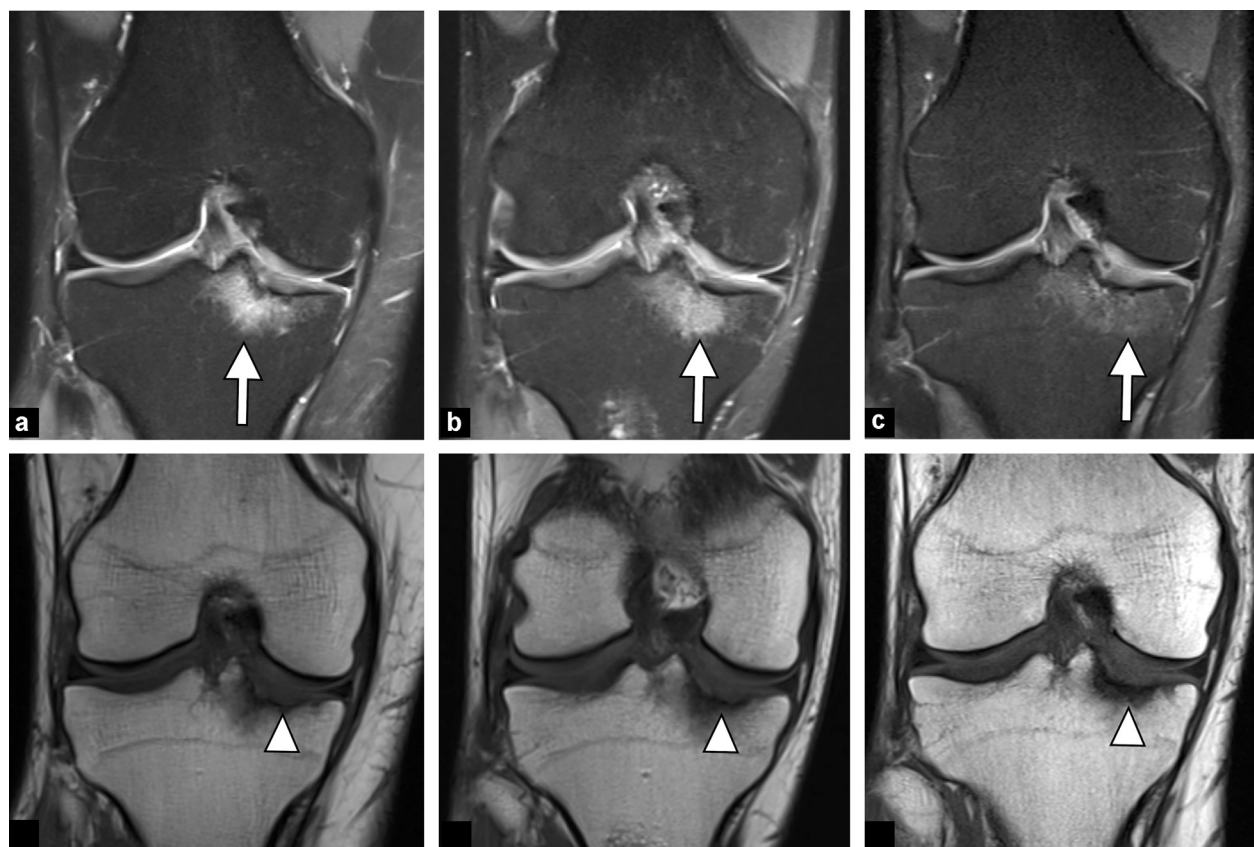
Evolution after microfractures on the tibial aspect of the medial femorotibial segment. Coronal fat-suppressed PD-weighted MR images (a–c) and T1-weighted (d–f) after 1 month, 4 months and 2 years, respectively. Decrease of the subchondral edema-like signal (arrows) and persistent irregularity of the subchondral bone plate on T1-weighted images (arrowheads).
